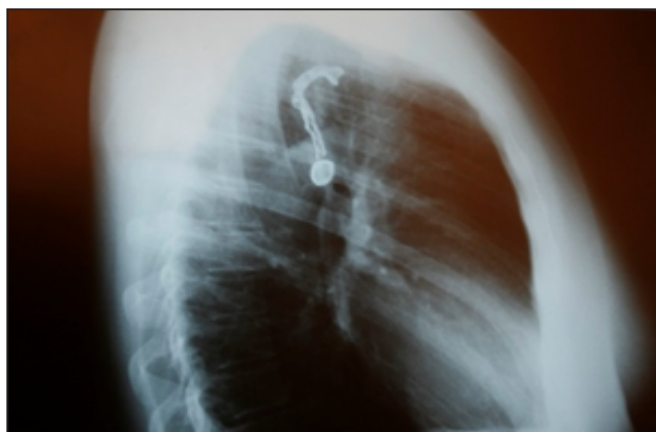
Lateral thoracic radiograph identifying the foreign object in the upper esophagus.
